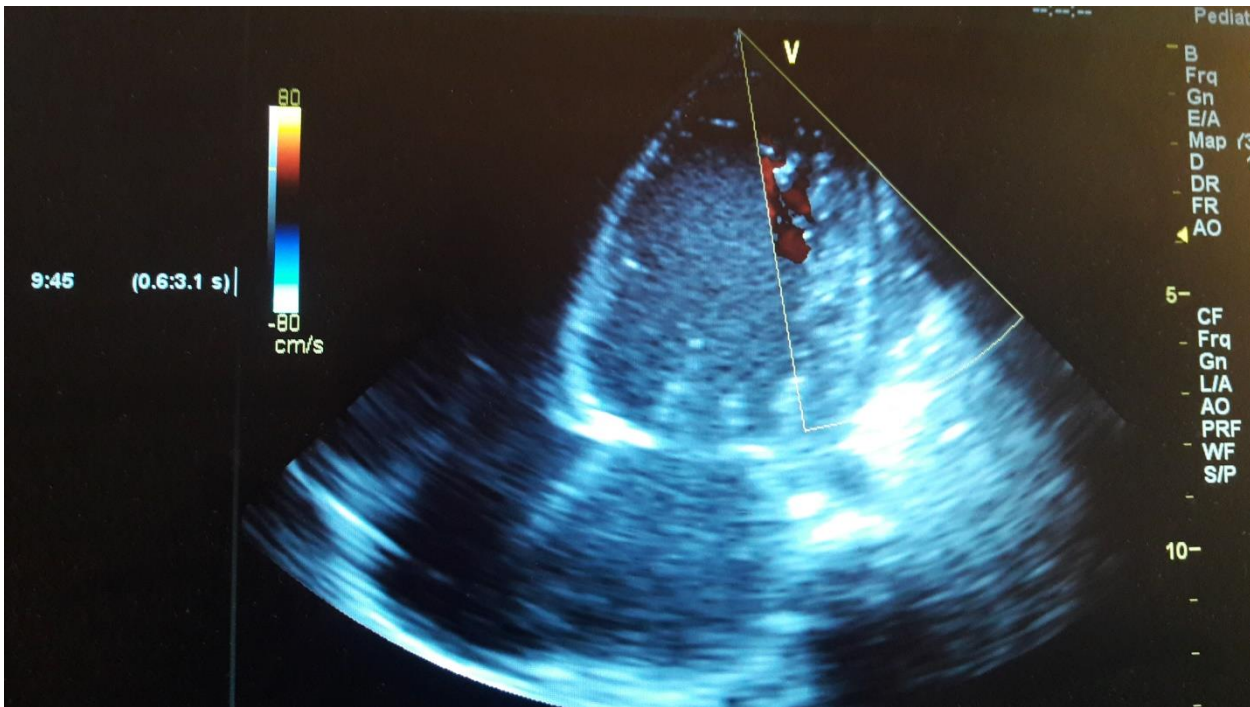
Apical 4-chamber echocardiographic view of same patient with color Doppler demonstrating communication of intertrabecular recesses with the ventricular cavity. Original clinical image from UATH non-invasive cardiac laboratory.
